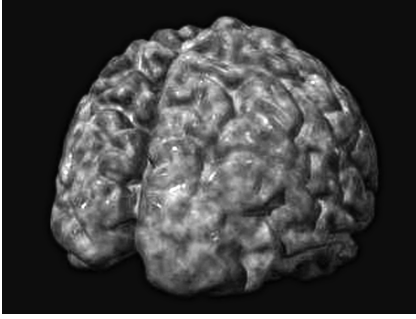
The iso-surface visualization of cortical convolutions of the human brain computed from the MRI brain volumetric data.
